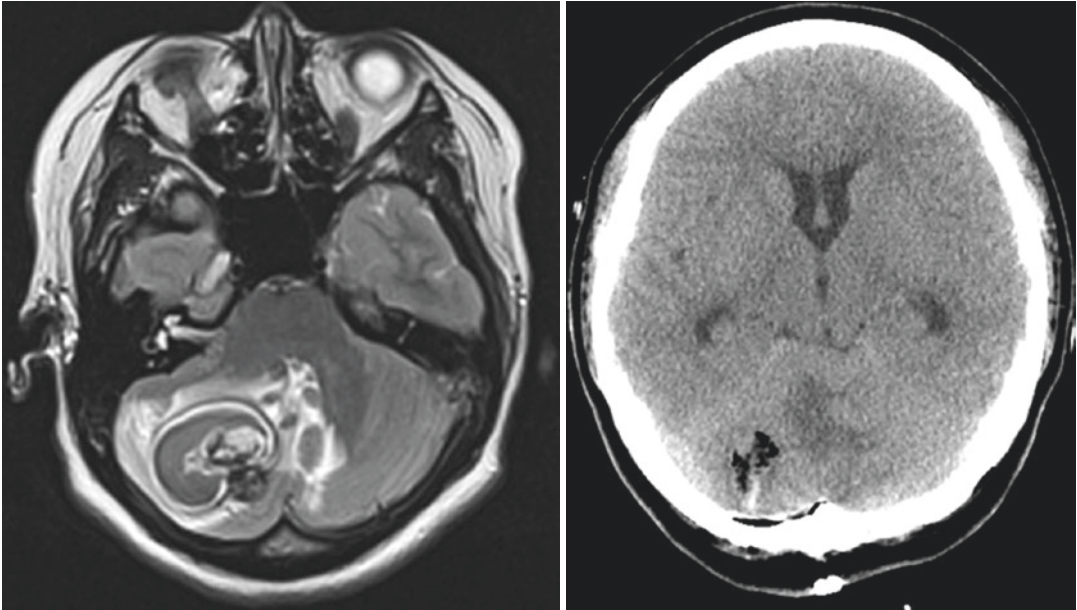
An 18-year-old girl developed sudden dizziness, headache, and gait ataxia. Left image: T2-weighted MRI showed heterogeneous (dark, iso, high) lobulated signals suggesting multistage hemorrhages that were surrounded
